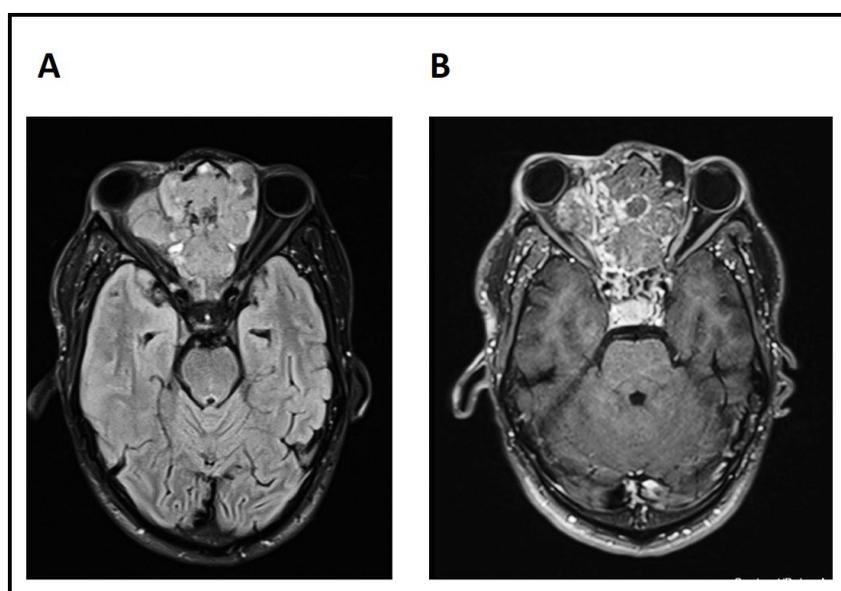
Brain MRI of patient 5 in axial T1 and T1 Gado sequences, showing an ethmoido-nasal aggressive tumor with extension towards the right orbit and heterogeneous contrast enhancement after Gadolinium injection
